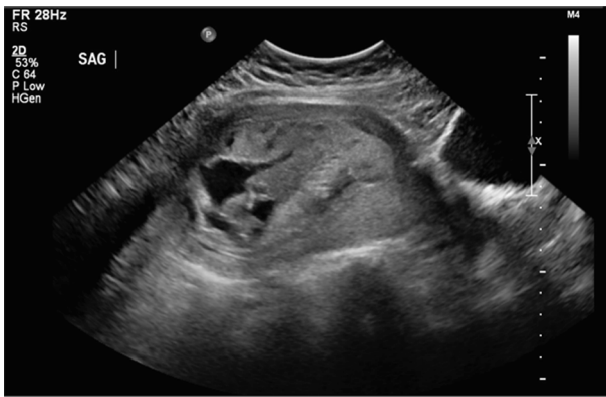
Pelvic ultrasound showing an enlarged uterus with heterogeneous material.
